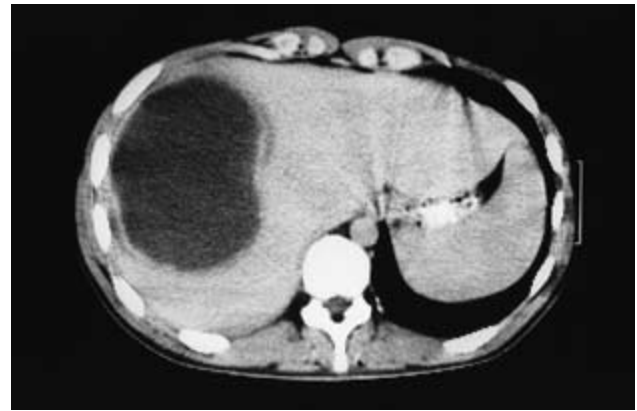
CT scan of the liver in a 21-year-old man with fever and right upper quadrant pain. The CT shows a large space-occupying lesion from which 1 litre of pus was drained. This was an infected amoebic abscess.
